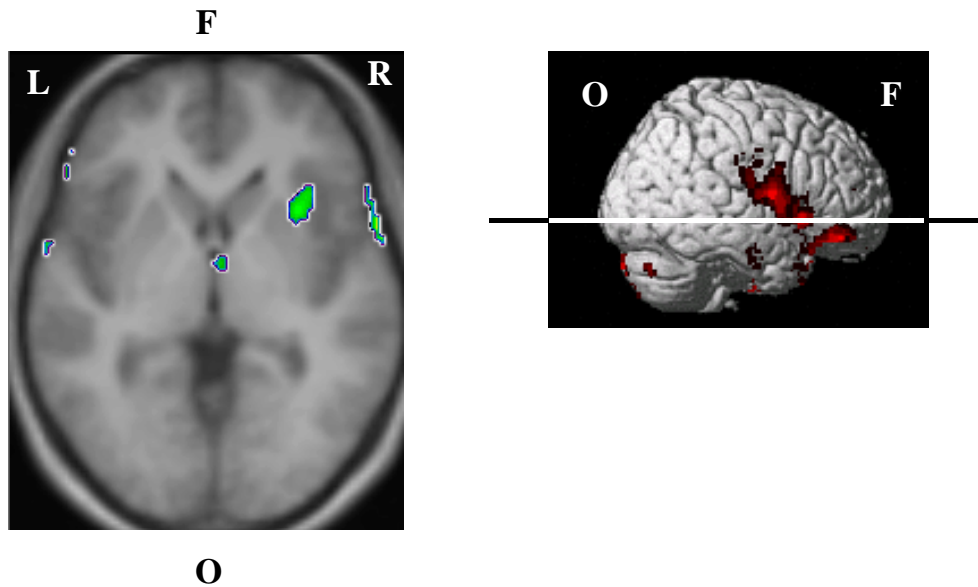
Right horizontal section (mean MRI image; section at -2 mm as demonstrated in the right image) through clusters with increased activation in right insula (anterior part), right thalamus and bilateral gyri postcentrales. Activation pattern during maximal distention relative to baseline (subtraction analysis: maximal distention condition – baseline condition). Analysis was run at the $p_{\text{uncorrected}} < 0.001$ level. Only the activation of the insula was significant at the $p_{\text{corrected}} < 0.05$ level. (F = frontal, O = occipital, L = left, R = right)
